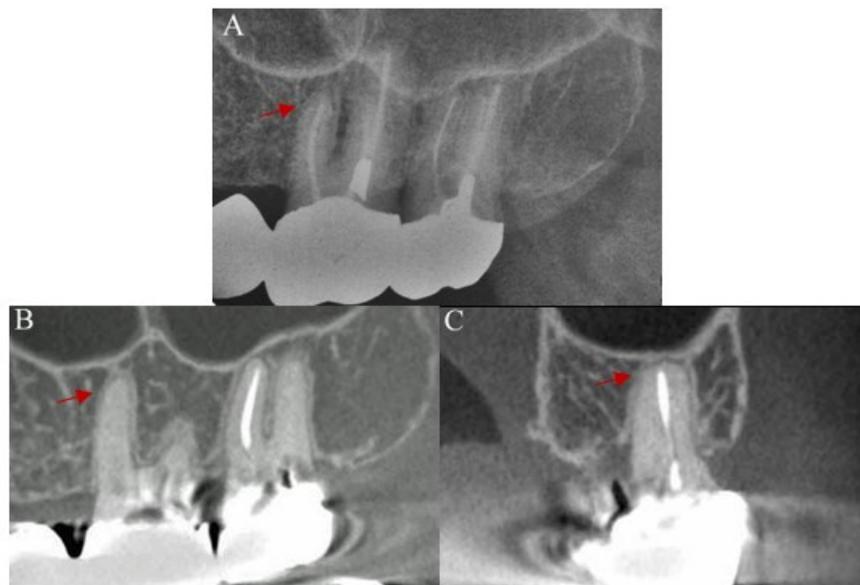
Comparison of PAI score between periapical radiograph and CBCT of tooth 27. Periapical radiograph of tooth 27 (A) shows small radiolucent area at apical region of mesial root, widening of periodontal ligament space, and loss of lamina dura integrity (PAI score 3). CBCT image of tooth 27 shows on sagittal (B) and coronal (C) view of tooth 27 there are no sign of periapical lesion on mesial root (PAI score 1).
